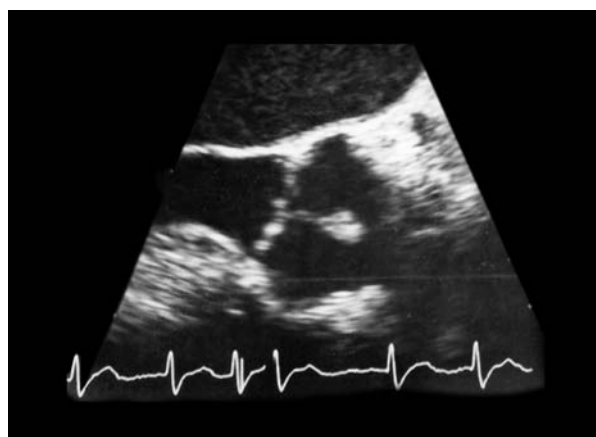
Preoperative transesophageal echocardiogram shows only the larger cardiac papillary fibroelastoma adhering to the free edge of the left coronary cusp.
